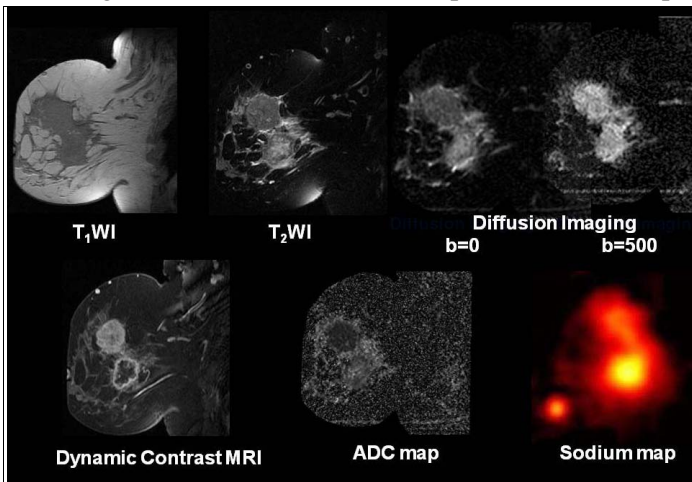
Representative 43y/o patient with a T3N1 lesion. Multiparametric T1- and T2-weighted, DCE, DWI/ADC, and Sodium images, demonstrating a heterogeneous breast lesion. The superior (12 o'clock) lesion has a homogenous enhancement with decreased ADC and lower TSC. The deep lower lesion exhibits rim enhancement and increased ADC with higher TSC.
